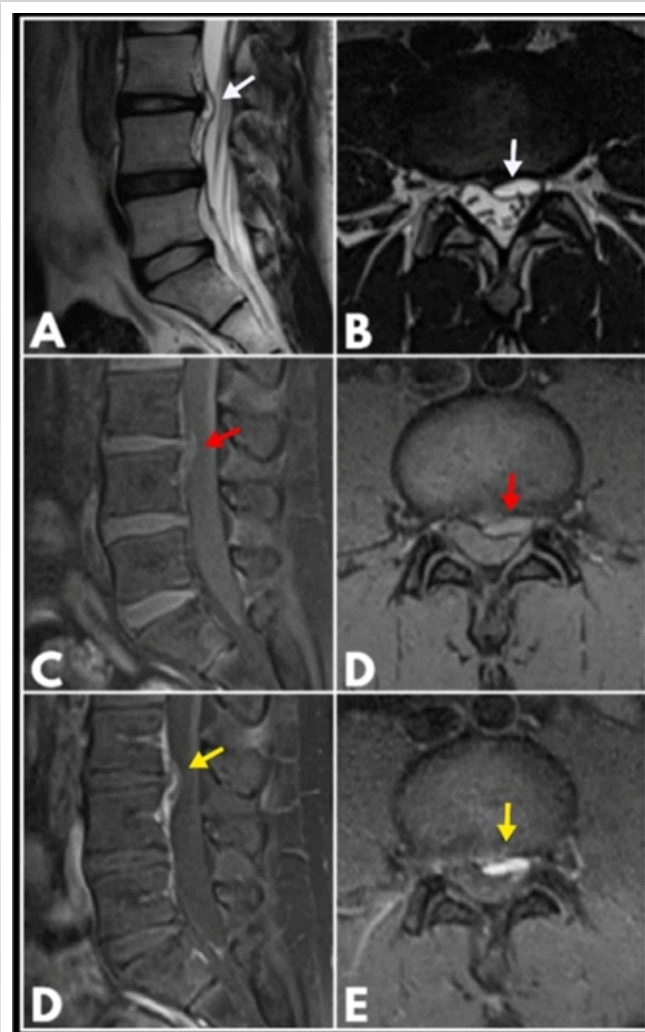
T2-weighted magnetic resonance imaging (MRI) sequences (a and b) demonstrating a hyperintense left paracentral discal cystic lesion at the L3–L4 level (White arrows). T1-weighted MRI sequences (c and d) (red arrows). Post-contrast images demonstrating gadolinium enhancement with septations within the cyst (e and f) (Yellow arrows).
